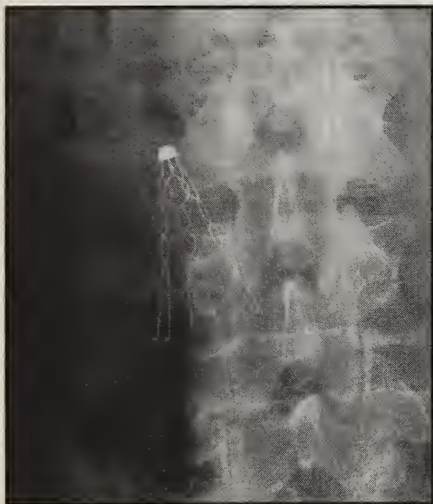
Abdominal radiograph demonstrates the KG filter to be tilted in the IVC with slightly prominent leg spread.
